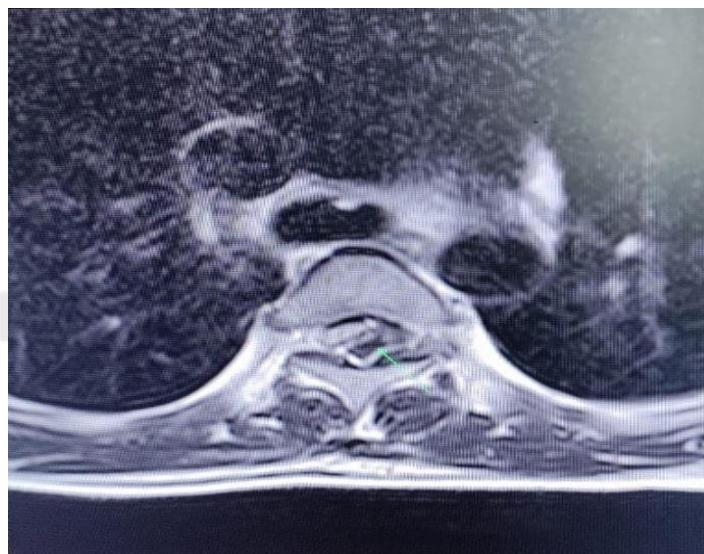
Magnetic resonance imaging (MRI) transverse section at D3-D4 shows right anterolateral compressive changes suggestive of reduced canal diameter.
